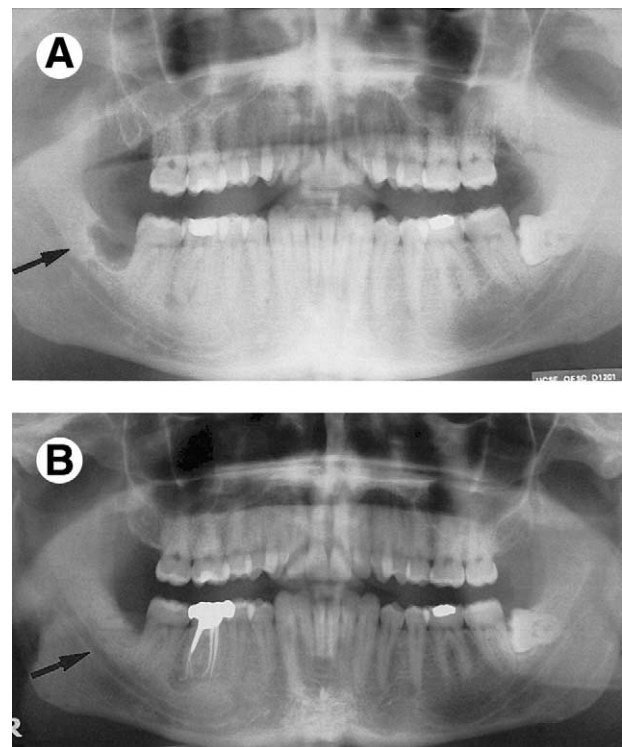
A, Radiograph of lower right third molar immediately postoperatively and B, radiograph 6 months following coronectomy showing bone formation over the retained root of lower right third molar.
